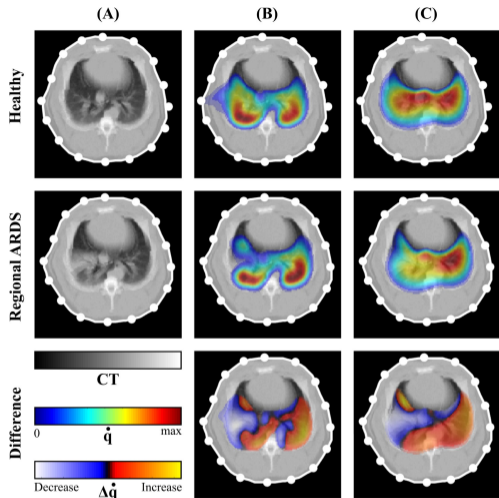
Regional blood flow distribution before and after regional lung injury by endotoxin. Grayscale CT images (A) are depicted together with computed MDCT blood flow  $q_{CT}$  (B) and computed EIT blood flow  $q_{EIT}$  (C) for the healthy state (upper) and for the injured lung (middle) Perfusion changes ( $\Delta q_{CT}$  and  $\Delta q_{EIT}$ ) after regional lung injury compared to the healthy state (bottom).
